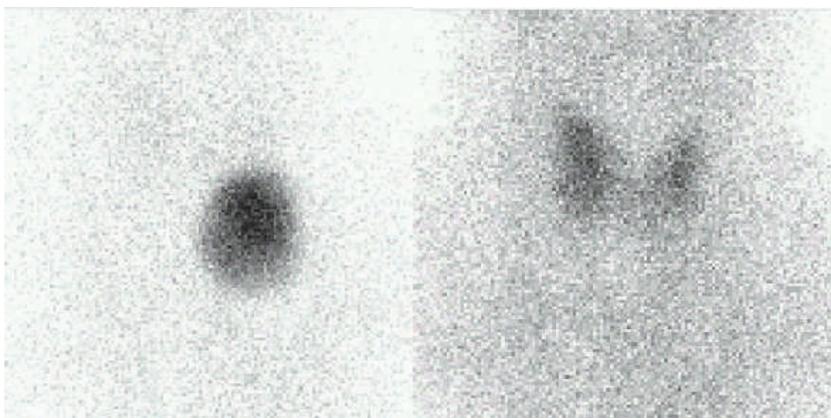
Thyroid scintigraphy - autonomous adenoma before (on the left) and after (on the right) successful RAIT
